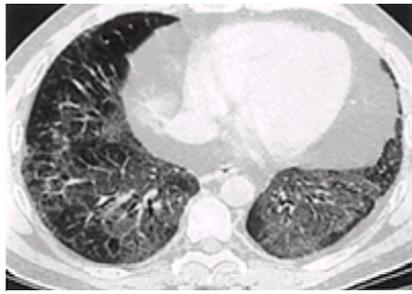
High-resolution computed tomographic image of basal regions of lungs in bronchiolitis obliterans associated with rheumatoid arthritis. Diffuse but patchy “ground-glass”-type infiltrates are well seen.
